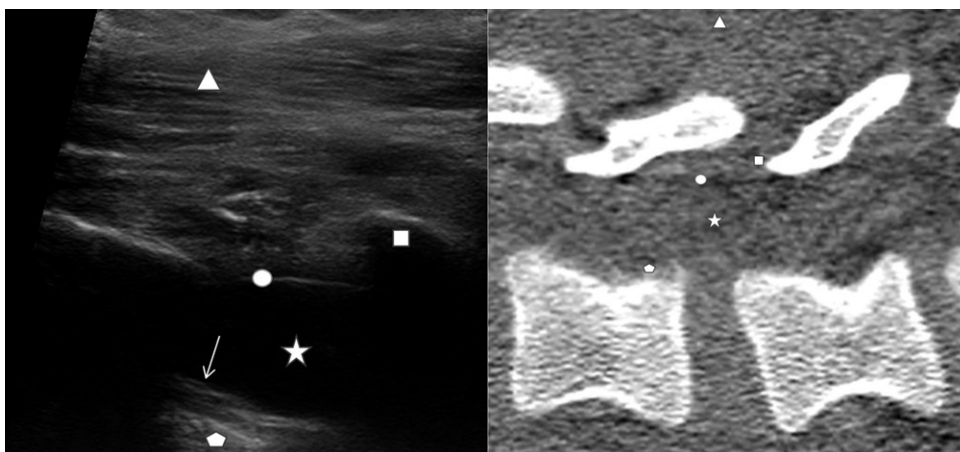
Ultrasound (right) and corresponding anatomical CT (left) images of the lumbar spine in a paramedian longitudinal oblique approach. Star: cerebrospinal fluid in the intrathecal space; circle: thecal sac; square: bony facet; arrow: nerve roots within the csf; triangle: paraspinal musculature; pentagon: posterior aspect of vertebral body/posterior longitudinal ligament.
